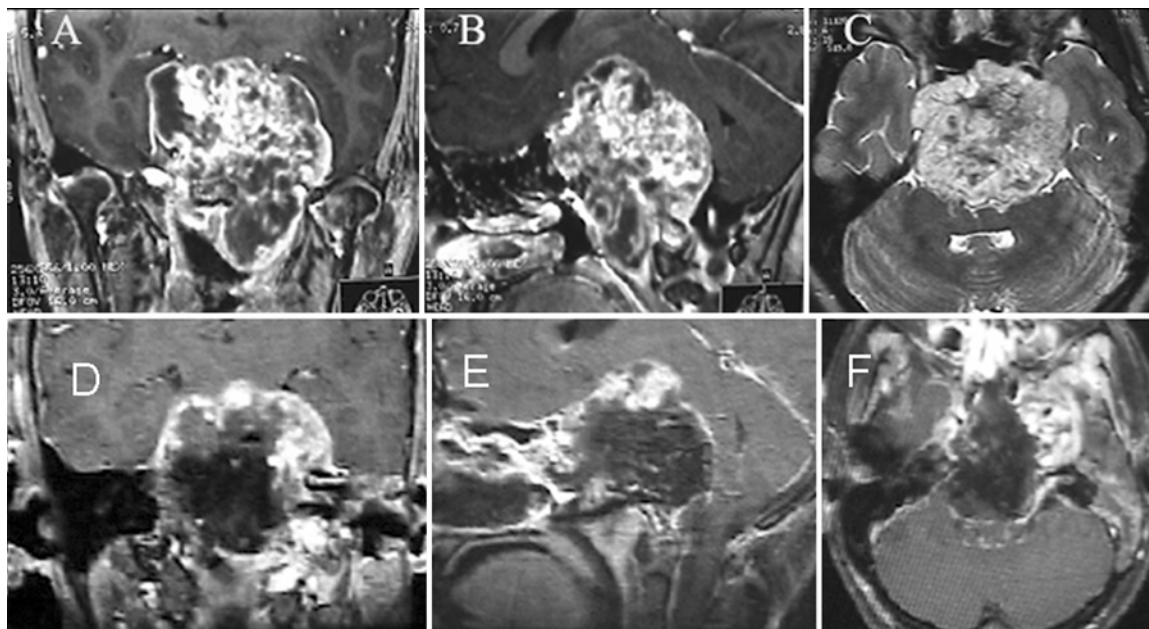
Preoperative and postoperative T1-weighted MR images. A–C: Preoperative coronal, sagittal, and axial images showing a chordoma involving the entire clivus, with bilateral cavernous sinus involvement and impressive suprasellar and posterior displacement of the brainstem. D–F: Postoperative axial, sagittal, and coronal images demonstrating the adequate removal of the tumor located at the midline, and the lateral limitation of the approach.
